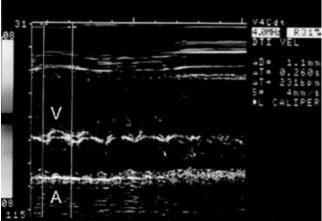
Tissue color Doppler imaging. (Reprinted from Cotton,³⁶ Copyright (1997), with permission from Lippincott Williams & Wilkins.)
